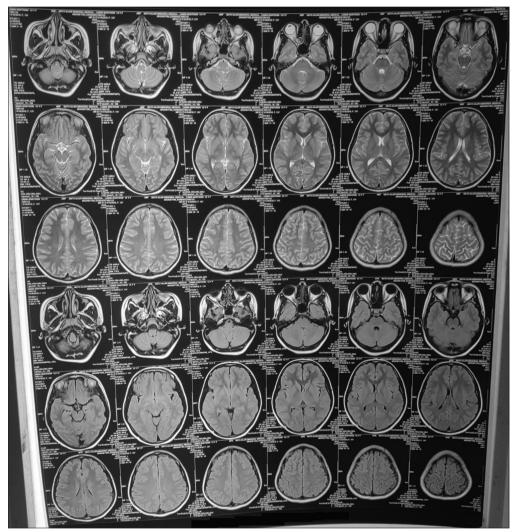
Magnetic resonance imaging brain with orbit (contrast)
